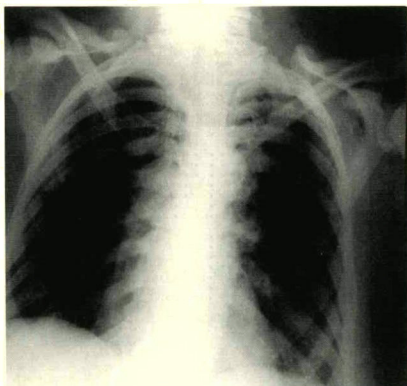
Slightly overpenetrated chest radiograph demonstrating diffuse dense symmetrical sclerosis of bony thorax.
